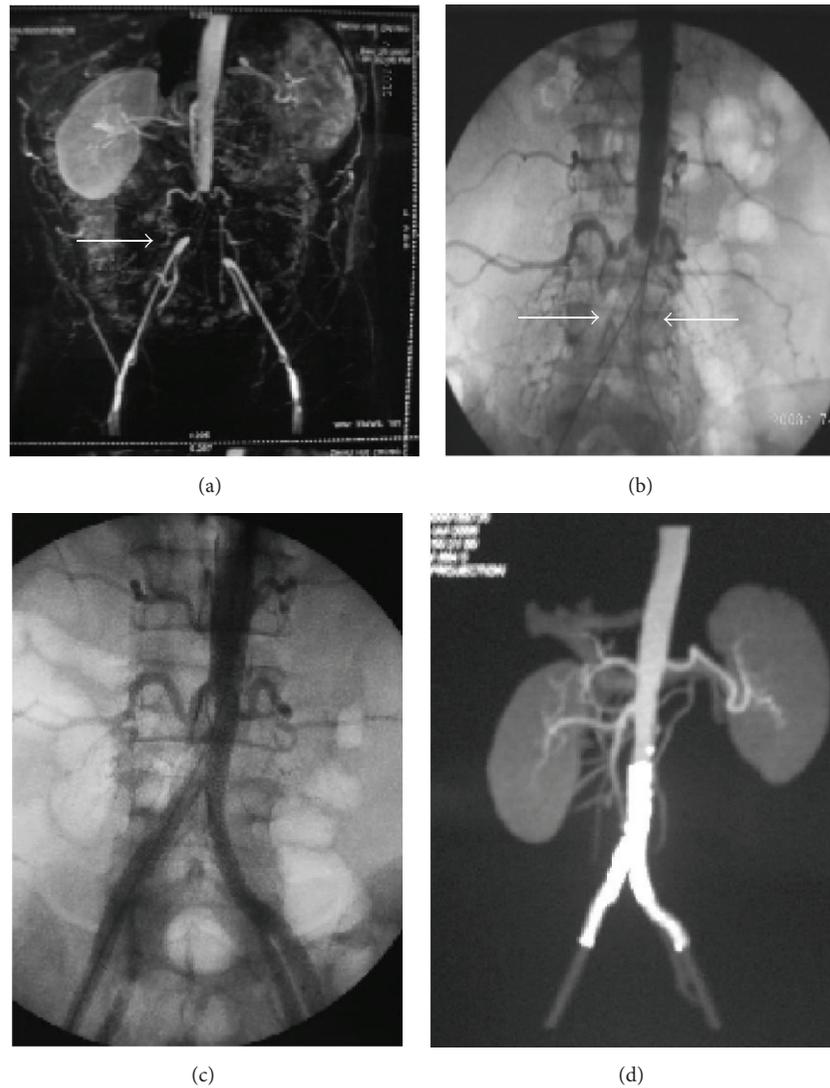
Stenting for a male PAD patient of 46 years. (a) CTA showed aorta-iliac artery occlusion lesions (arrow). (b) Two guide wires pass to aorta-iliac artery from bilateral femoral artery (arrows). (c) After dilation by balloon, Kissing-stents placement involving the distal aorta and bilateral common iliac is performed. (d) Excellent result.
